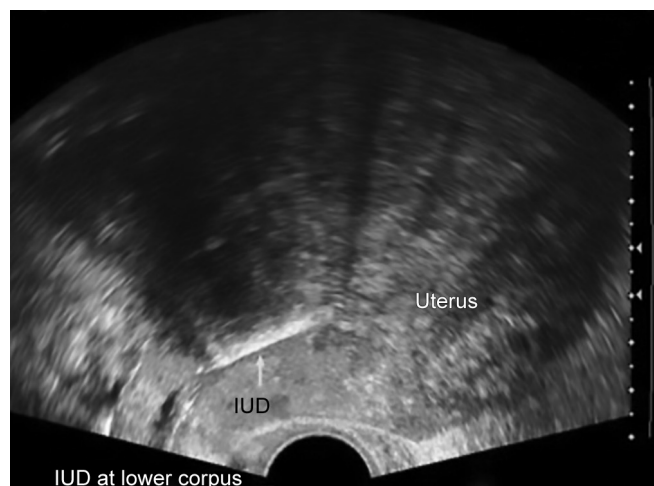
Intrauterine device in the uterine cavity in sonogram
